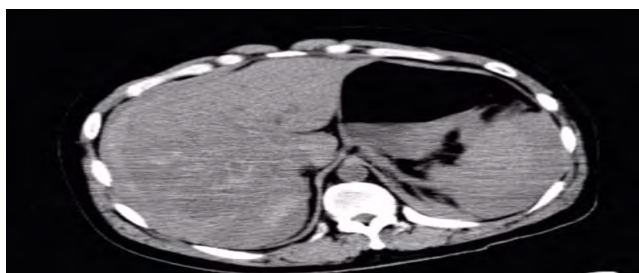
Three hours after injury, CT scan in our hospital indicated liver trauma with moderate amount of fluid in the abdomen.
